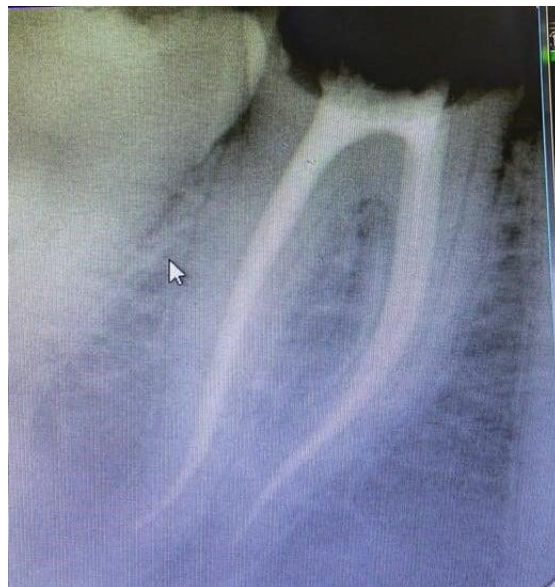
Preoperative intraoral periapical radiography
